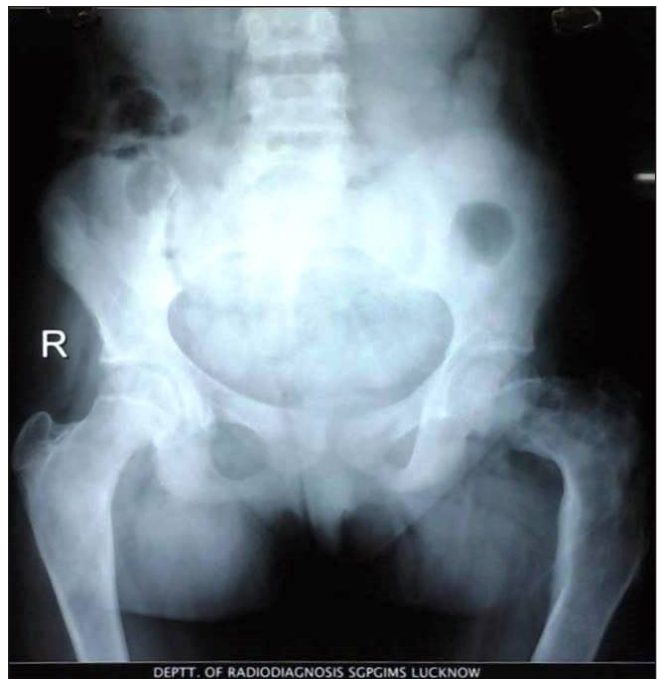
X-ray pelvis AP view showing expansile radiolucent lesion with sclerotic foci in neck and metaphysis of B/L femur with shepherd's crook deformity on left side.
